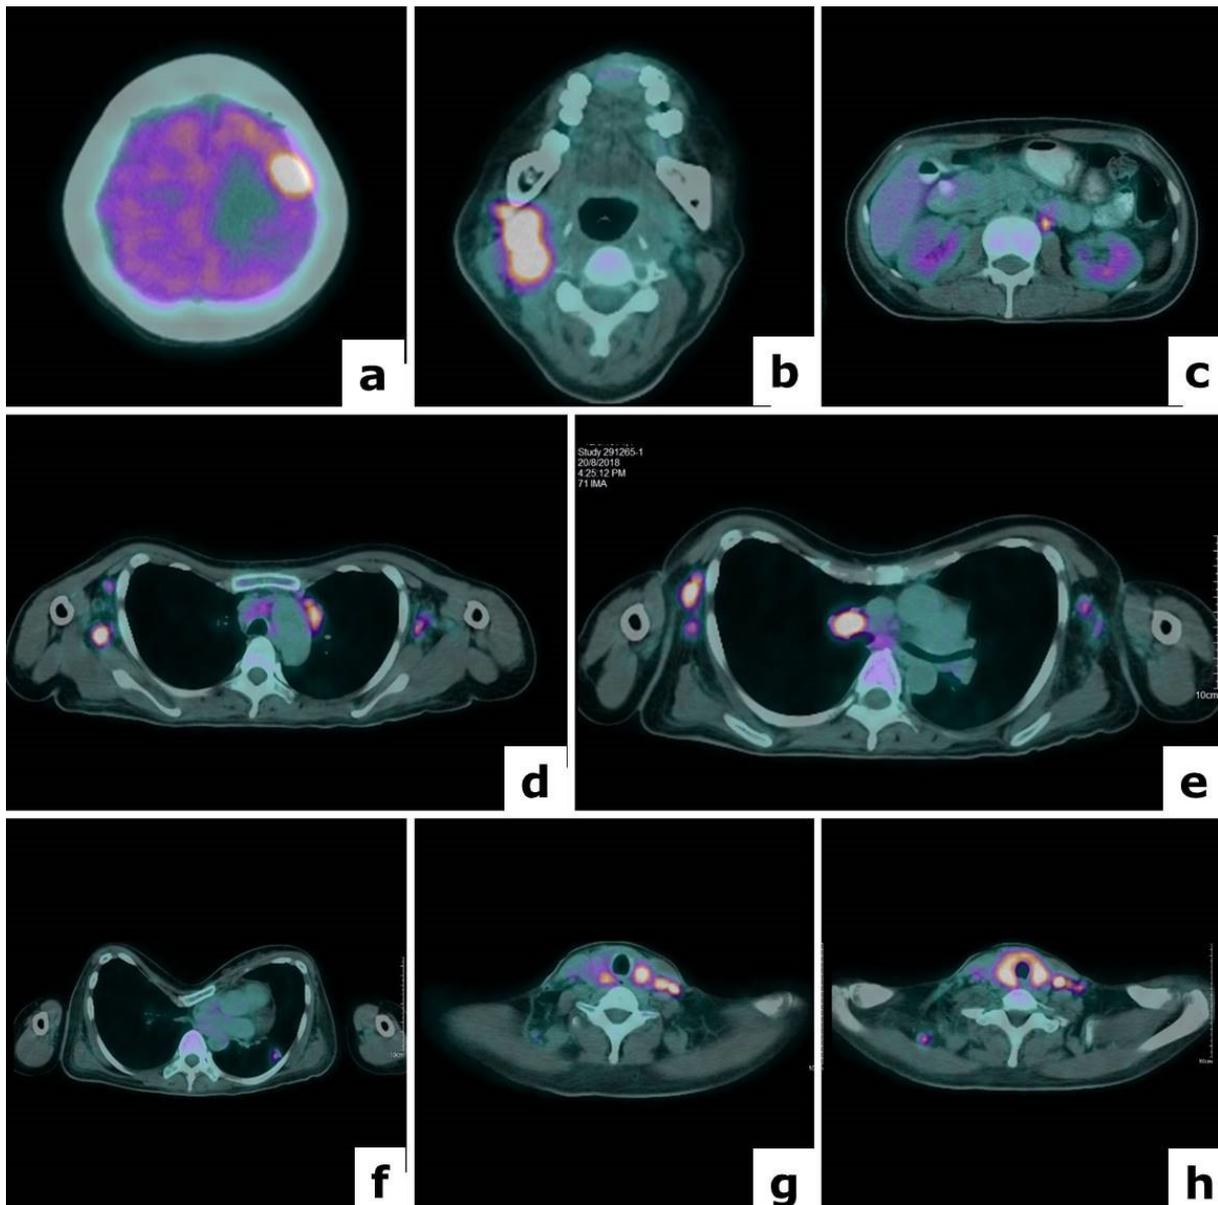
PET/CT showing uptake at (a)Left frontal lobe of cerebrum (b) Cervical nodes (c) Abdominal para-aortic node. (d) Mediastinal and bilateral axillary nodes (e) Hilar node (f) Left lower lobe of lung nodule (g) Bi-lateral cervical nodes (h) Thyroid gland. (Click to enlarge)
